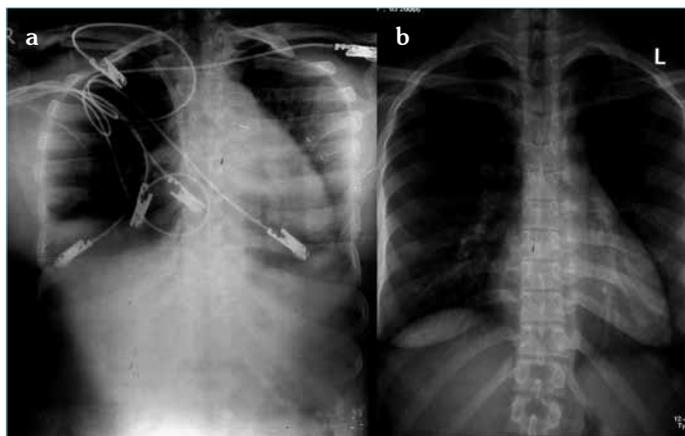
a, b. Chest X-Ray of patient.
